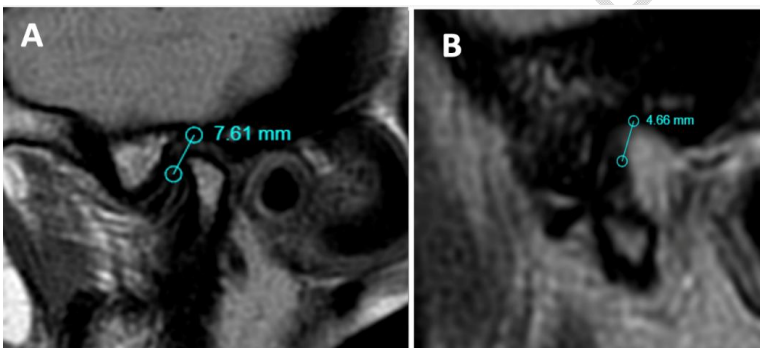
Protocol for measuring the articular disc on magnetic resonance imaging, (A) mouth closed, (B) mouth open
